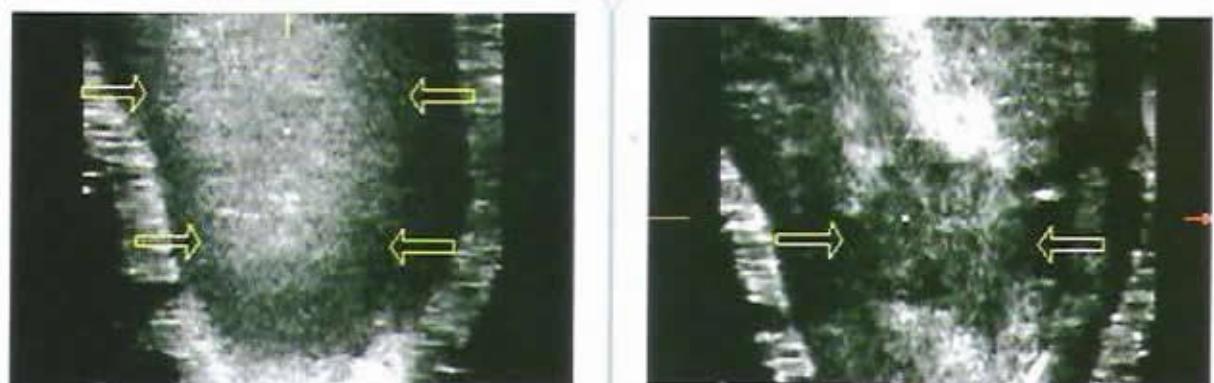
NORMAL DEEP FLEXORTENDON VISUALIZED WITH 3-D ULTRASOUND
